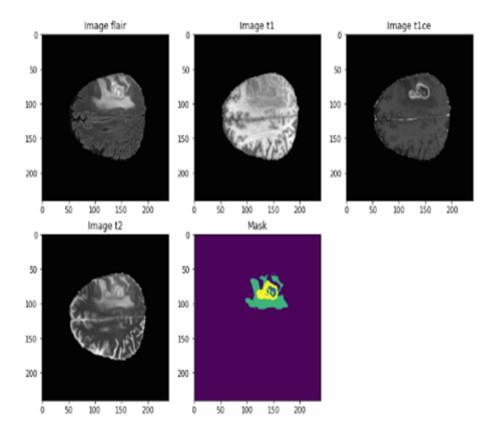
Visualistaion of the MRI modalities
